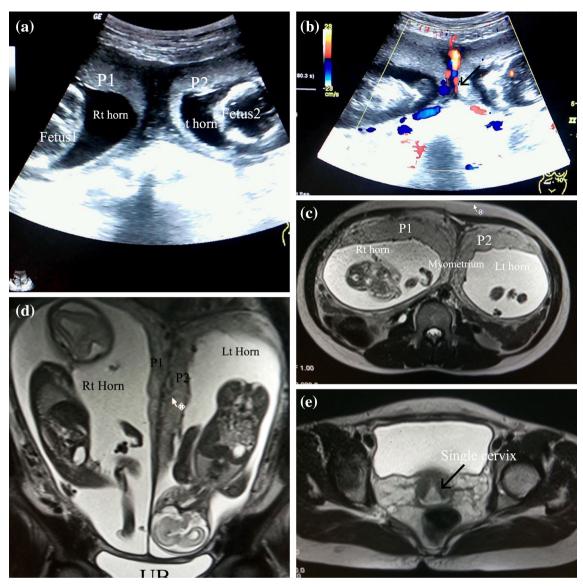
(a) Sonographic image showing two uterine horns separated by thick myometrium with fetal parts in each cavity with two anterior wall placentae (P1 and P2) in each horn. (b) Doppler image showing the flow in the intervening uterine tissue (Black arrow) of the two
